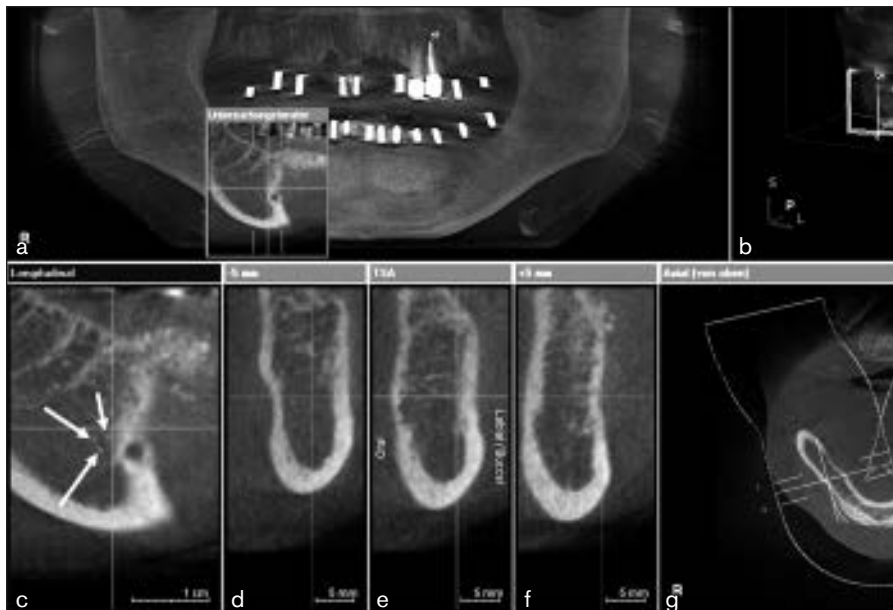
Postoperative CBCT of Case 9. (a) Panoramic view window with inset showing an enlargement of the mental foramen. (b) Parts of the 3D reconstruction of the CBCT (marks indicate the transversal cuts shown in d, e, and f). (c) Multiple particles directly in front of the mental foramen in close contact with the mental nerve (arrows), causing NCS. (g) Axial view of the mandible with transversal slices in the middle.
